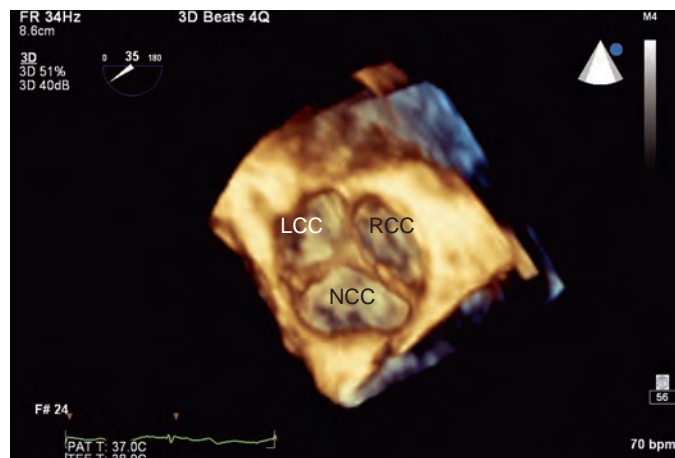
Three-dimensional transesophageal echocardiographic image of the aortic valve displayed in the surgeon's view. LCC, Left coronary cusp; NCC, noncoronary cusp; RCC, right coronary cusp.
